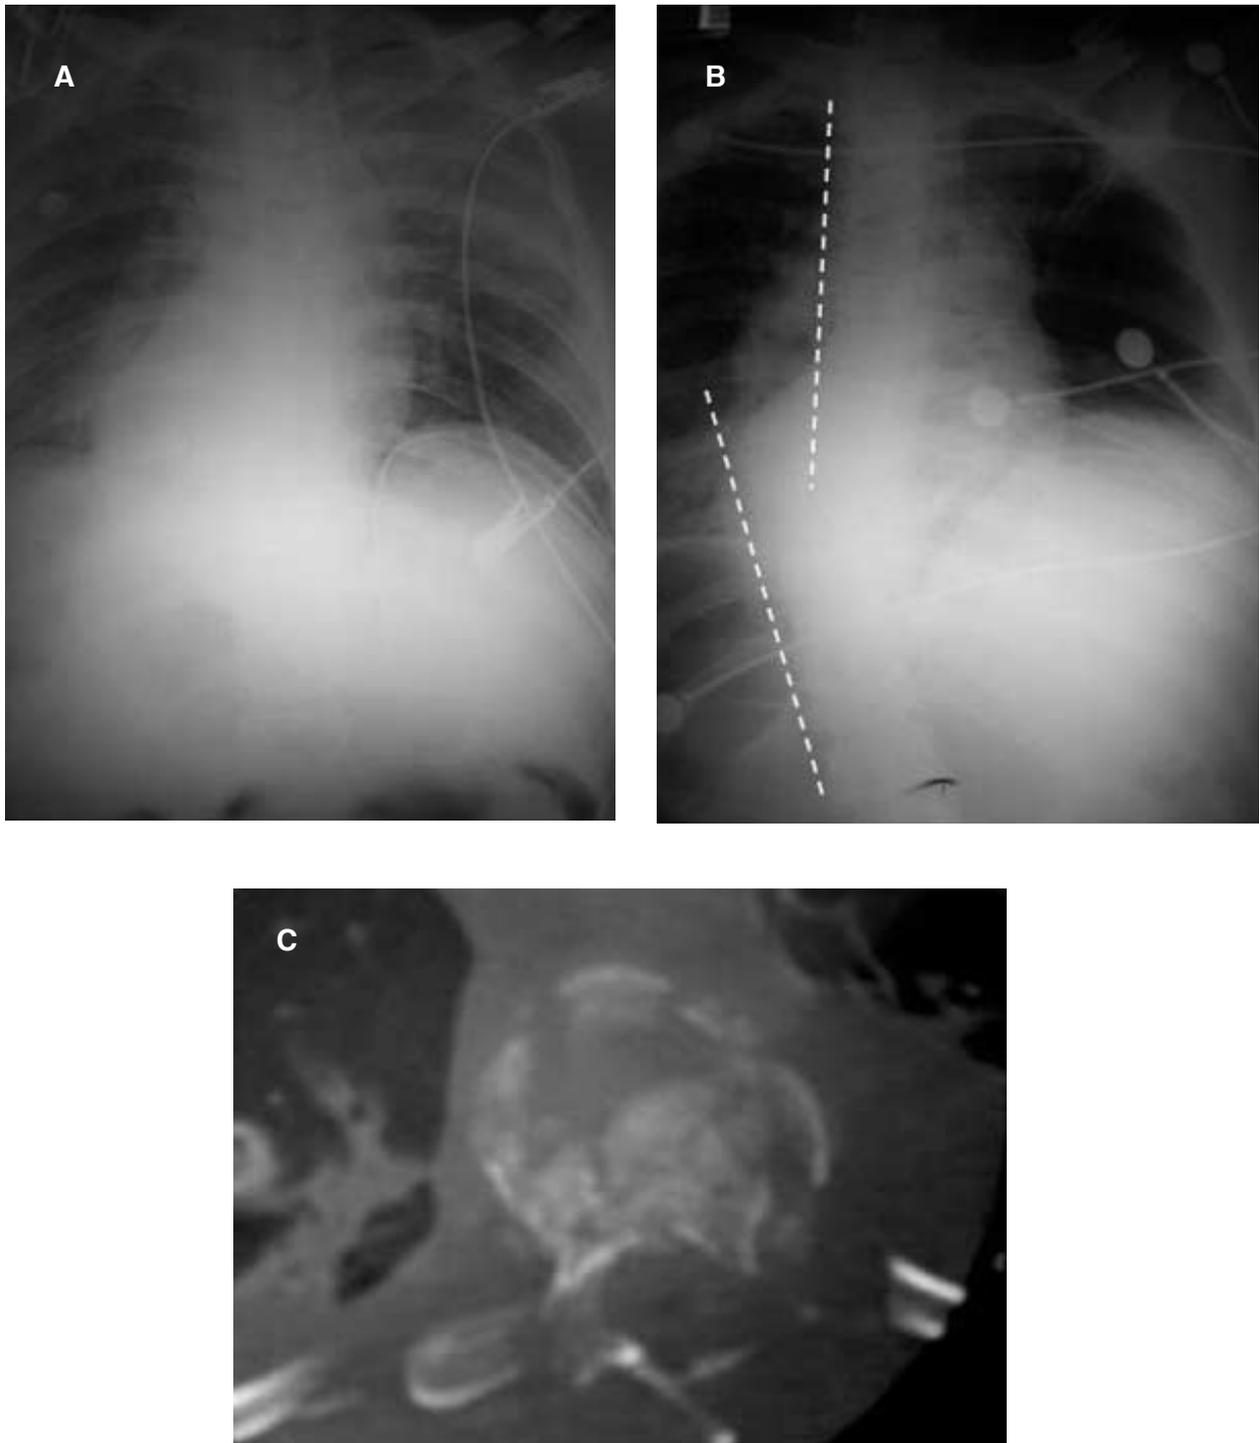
Initial supine chest radiograph (A) of a 23-year-old woman who had blunt chest trauma in a motor vehicle accident; the patient was neurologically intact at the EC evaluation but her neurologic status was deteriorated in ICU and she demonstrated T9 paraplegia. Control radiography demonstrates acute angulation of the T9 with displacement of vertebral body fragments producing a "widened " T9 body. Computed tomography confirms a fracture of T9 with lateral translation (B and C).
